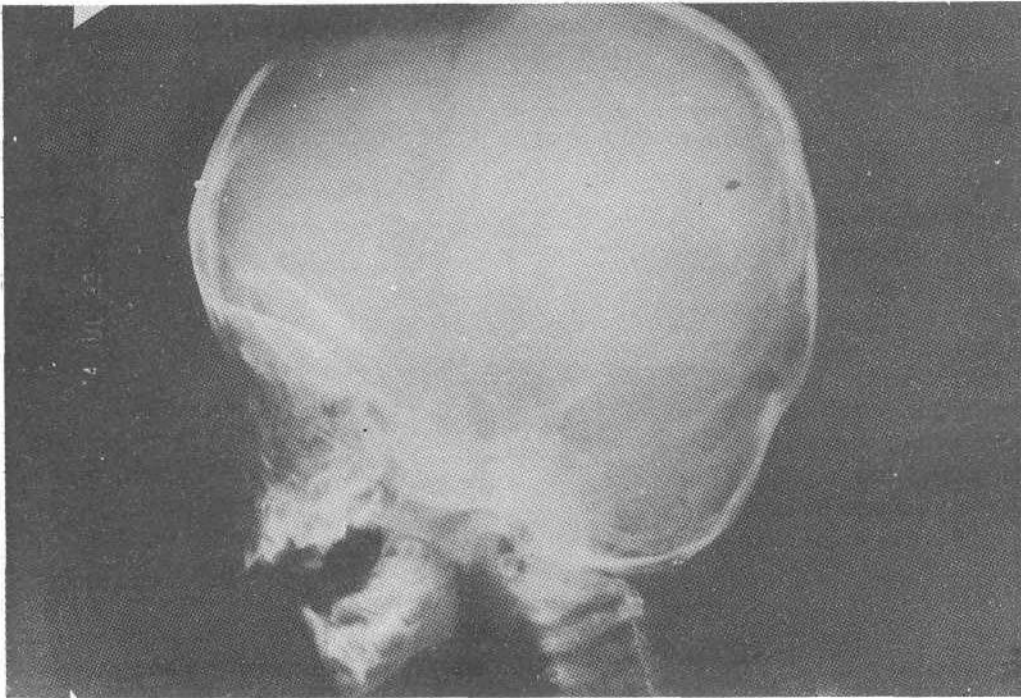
Radiograph of lateral view of skull showing sclerotic base of skull.
